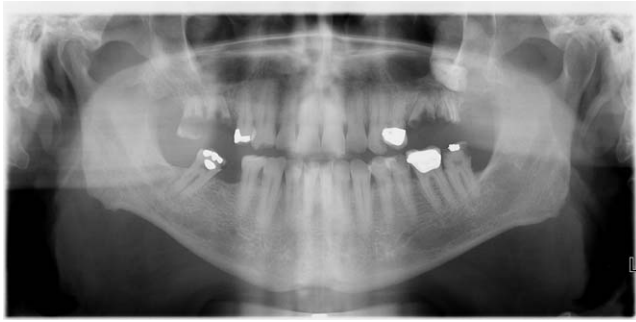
Panoramic radiography showing a two-dimensional representation of the curved surfaces of the maxilla and evidence of dental restorations in a patient with odontogenic sinusitis (see Fig. 3).
